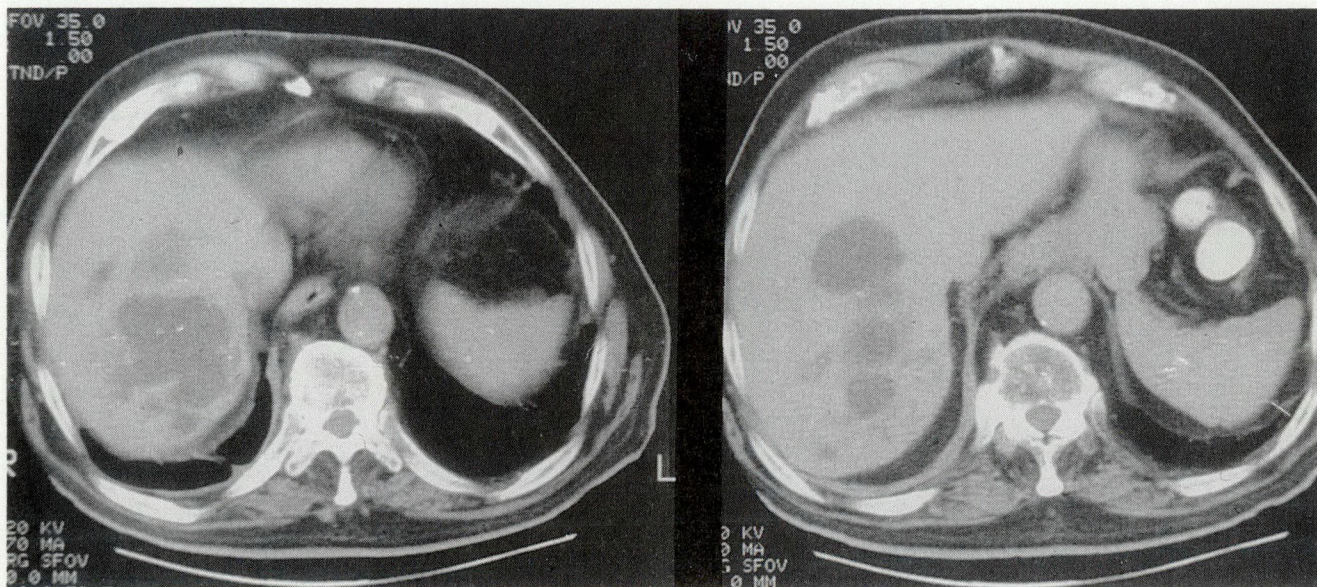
Computed tomography scan demonstrating multiple pyogenic abscesses in right hepatic lobe.
